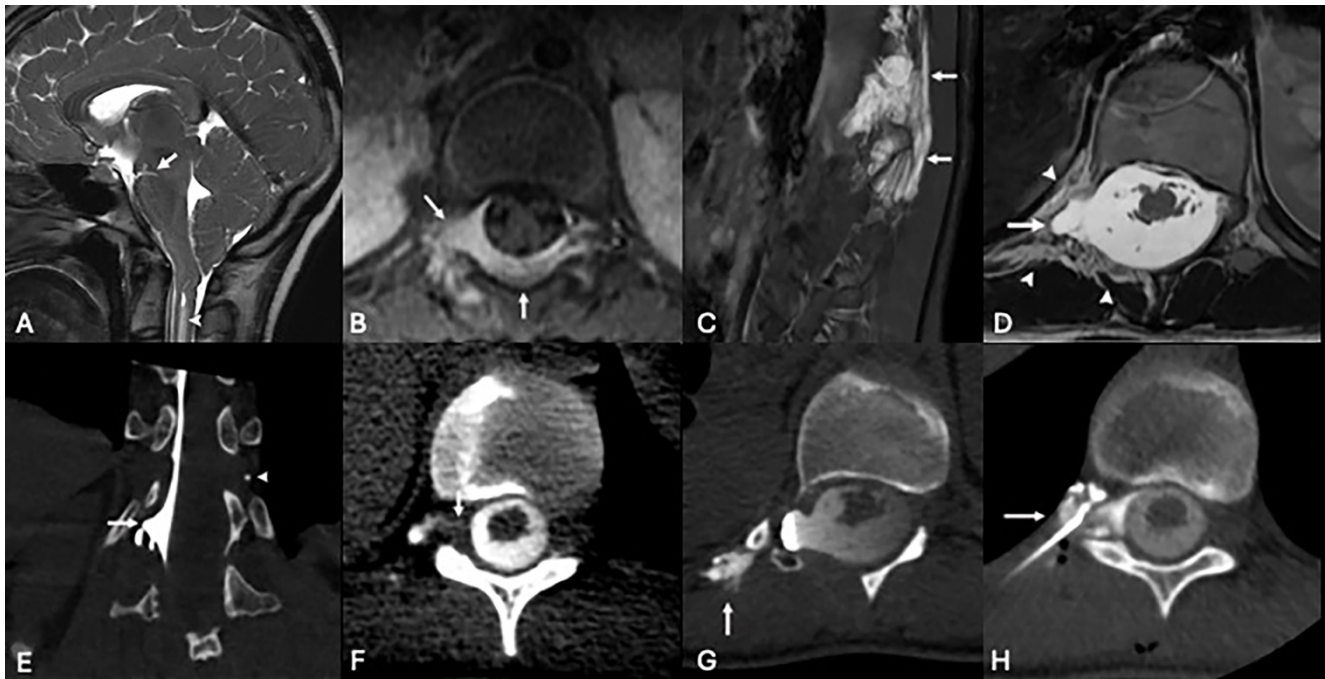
Patient 1: Spinal CSF-venous malformation fistula. A 23-year-old female had a history of an “epidural hematoma” at 18 months of age. 21 years later she developed postural headaches. *A*, Sagittal T2-weighted image of the brain shows severe mid brain sag (arrow), along with cerebellar tonsillar descent and a cervical cord syrinx (arrowhead). *B*, Axial contrast-enhanced fat-suppressed T1-weighted image at 18 months of age shows an enhancing lesion in the T12 epidural space (arrows) that extended into the right paraspinal soft tissues. *C*, Sagittal short tau inversion recovery image as an adult shows a large right paraspinal lesion (arrows) that was consistent with a venous malformation. *D*, Axial T2-weighted image shows the paraspinal venous malformation (arrowheads) and right dural ectasia at the T12 level (arrow). *E*, Right decubitus CT myelogram in the coronal plane shows opacification of the right T12 dural ectasia (arrow) but no leakage. A left-sided phlebolith is noted (arrowhead), which is consistent with the underlying paraspinal venous malformation that extended to the left side. *F*, *G*, Delayed myelographic images 3 minutes later show a right T11-T12 fistula between the thecal sac and the venous malformation (*F*, arrow) with additional opacification of the venous malformation more laterally near the ribs (*G*, arrow). *H*, Fibrin glue patch filling the CSF-venous malformation fistula (arrow) provided moderate relief.
